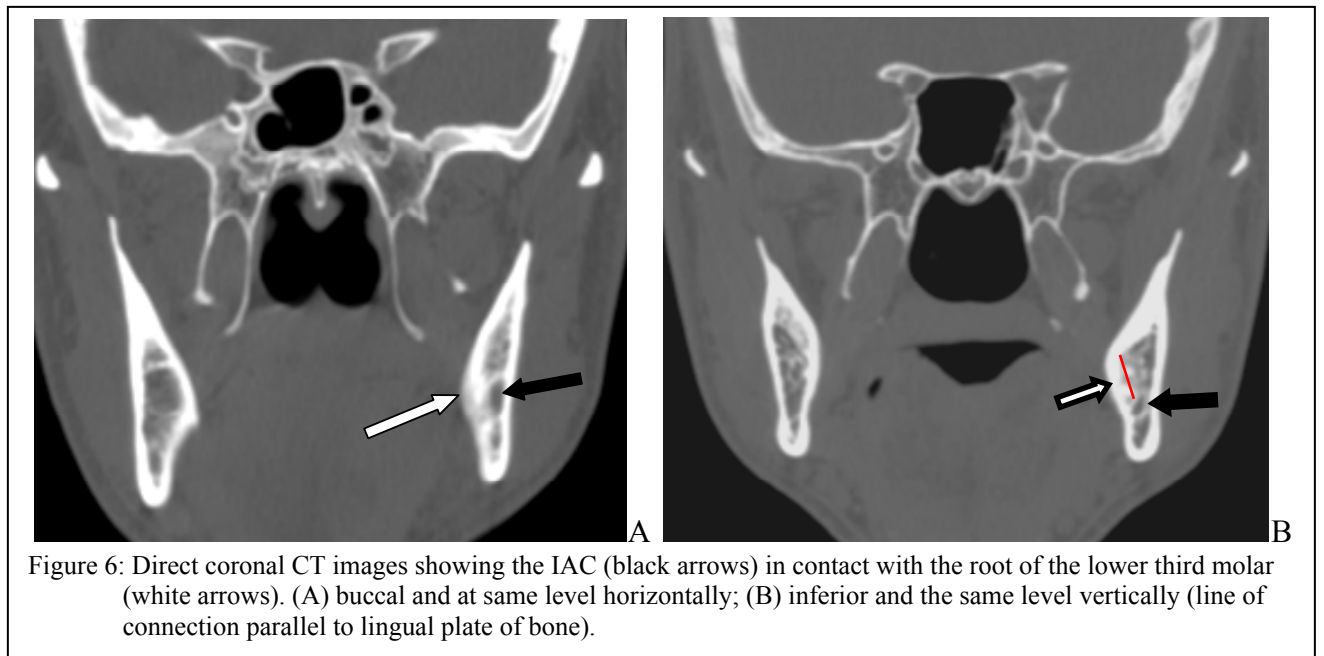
Direct coronal CT images showing the IAC (black arrows) in contact with the root of the lower third molar (white arrows). (A) buccal and at same level horizontally; (B) inferior and the same level vertically (line of connection parallel to lingual plate of bone).
